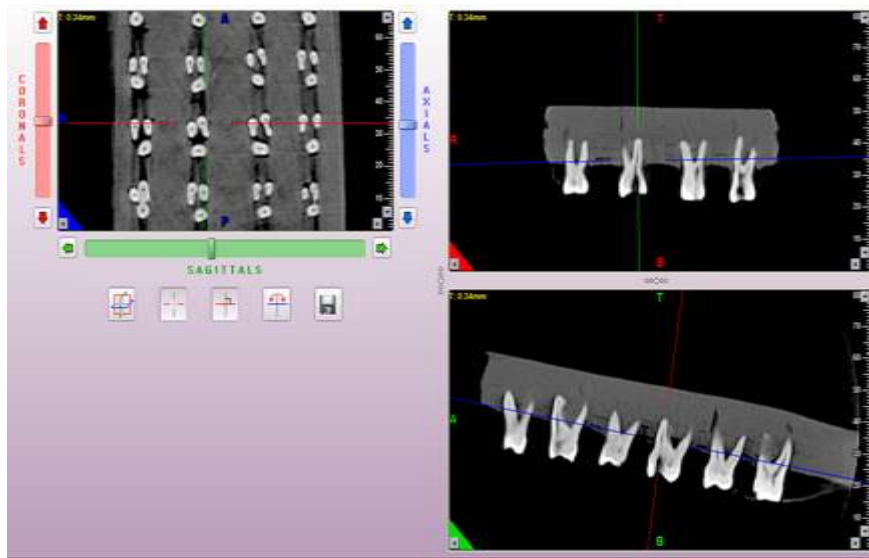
Post instrumentation CBCT (Longitudinal view)
